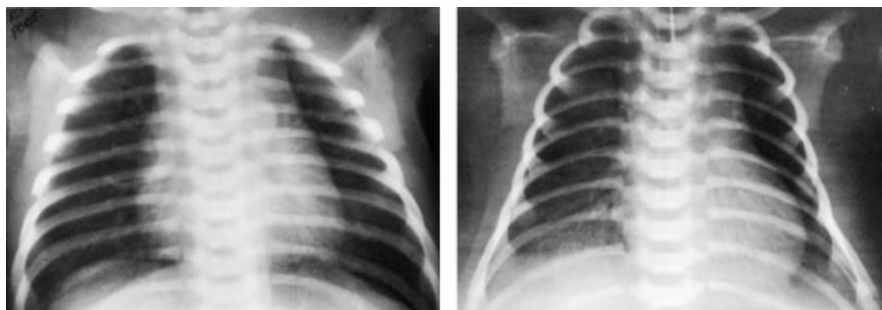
Chest x-rays of a normal preterm infant (*left*) and one with respiratory distress syndrome (*right*). Note the air bronchograms, the loss of lung volume and the heart border in the latter. *Source:* Courtesy of Dr Robert C. Brasch.
